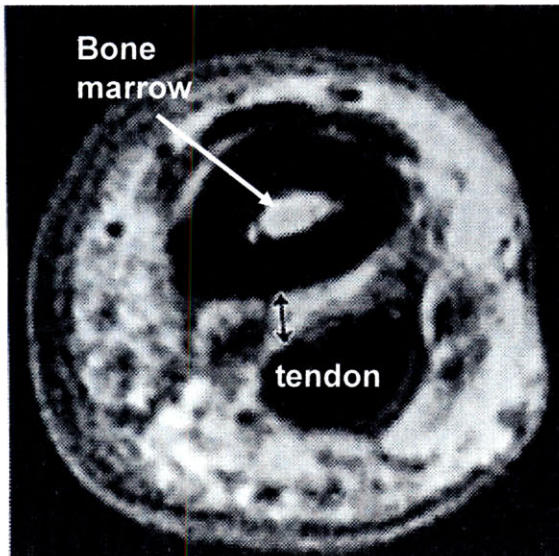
T1-weighted MRI of normal finger base [68].
